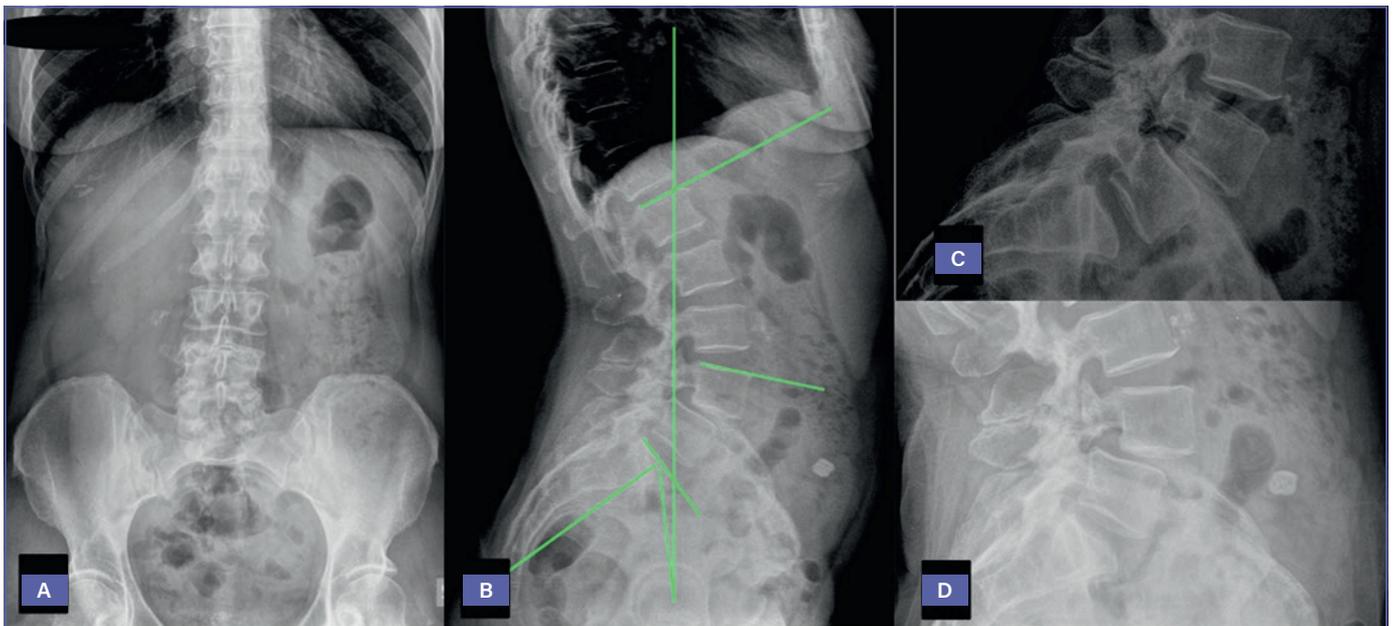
(A,B) antero-posterior and lateral lumbar standing radiographs and (C, D) dynamic flexion and extension lumbar standing radiographs showing L4 isthmic spondylolisthesis.
